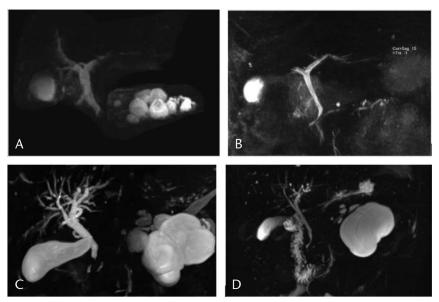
A and B, Magnetic resonance imaging scans showing presence and removal of PCLs in the first patient before and after steroid. C and D, Magnetic resonance imaging scans showing presence and partial response of PCLs in the other patient before and after steroid.
